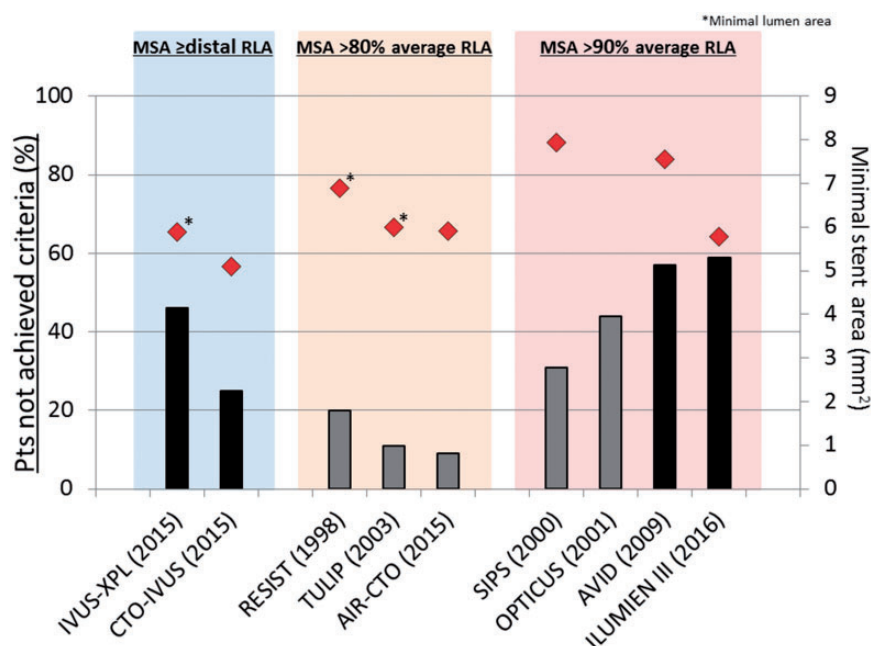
Effects of intravascular ultrasound-guidance and optical coherence tomography-guidance on stent expansion. Proportion of patients who did not achieve predefined criteria of stent expansion in selected randomized trials of intravascular ultrasound-guided and optical coherence tomography-guided interventions are shown by bars and the achieved minimal stent area (or lumen area indicated by asterisks) as indicated by the red diamonds. Trials are grouped according to the predefined stent expansion criteria. Black bars represent drug-eluting stents and grey bars represent bare metal stents. Minimum stent area values are means with the exception of ILUMIEN 3 (median). RLA, reference lumen area.
